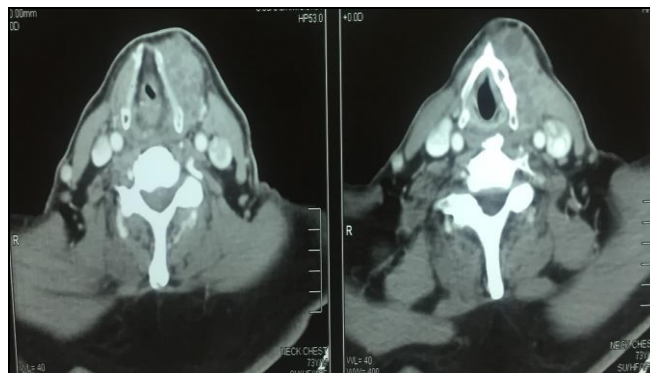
CE CT (Contrast-Enhanced Computed Tomography) Scan Neck Showing Mass in Left Thyroid Lobe
